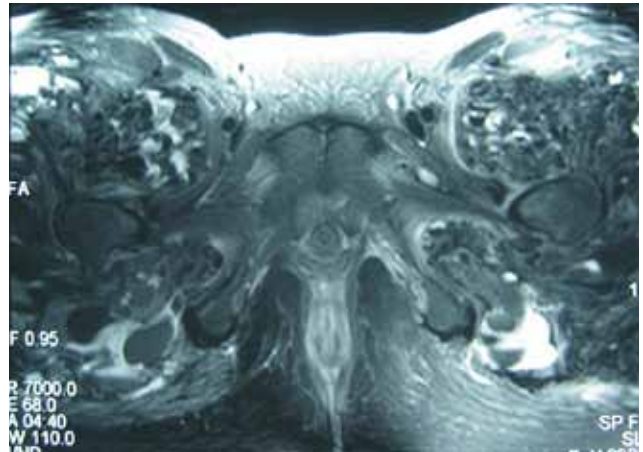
T₂-weighted magnetic resonance image shows diffuse calcium deposits around proximal femurs.
